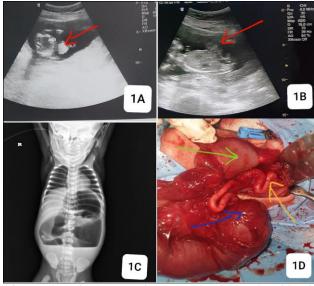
1A and 1B) antenatal scans at 16 and 20 weeks, with red arrow showing gastroschisis. 1C) plain abdominal erect X-ray with dilated small bowel and 3 air-fluid levels. 1D) intraoperative finding of dilated stomach (green arrow), jejunal atresia (blue arrow), and short length atretic colon (yellow arrow).
